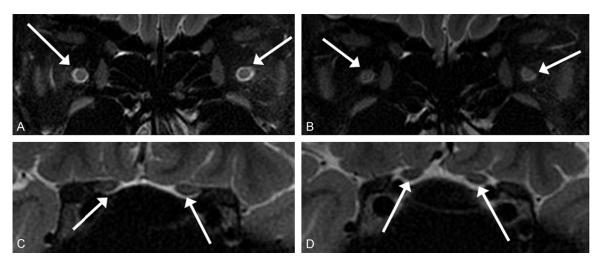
Coronal T2 MRI of retrobulbar (A, B) and prechiasmal (C, D) optic nerves. Arrows indicate increased signal in retrobulbar and prechiasmal without any enlargement.
